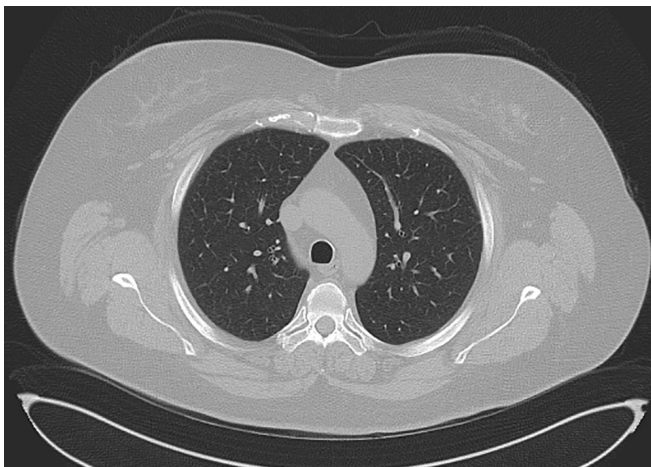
is a representative chest CT image from the time of hospital admission, showing diffuse centrilobular ground glass nodules in both lungs without any zonal predominance. There were no pulmonary emboli. The patient had substantial leukocytosis with neutrophilia (leukocytes 15.6 [normal 4.0–11.0]  $\times 10^9/L$ , neutrophils 12.0 [normal 2.0–7.5]  $\times 10^9/L$ ), a normal eosinophil count (0.2 [normal 0.0–0.5]  $\times 10^9/L$ ) and an elevated C-reactive protein (49 [normal < 8 mg/L]). Because interstitial lung disease was suspected, rheumatoid factor, antinuclear antibody, and cytoplasmic and perinuclear antineutrophil cytoplasmic antibody levels were ordered and were all negative. Brain natriuretic peptide and troponin levels, ordered by an emergency department physician, were within normal limits on both visits to hospital. Spirometry showed proportionate reduction in forced expiratory volume at 1 second (FEV1) and forced vital capacity (FVC), with no evidence of obstruction. Her FVC was 2.13 L (59% predicted), her FEV1 was 1.54 L (53% predicted) and her FEV1:FVC ratio was 72.3%.
